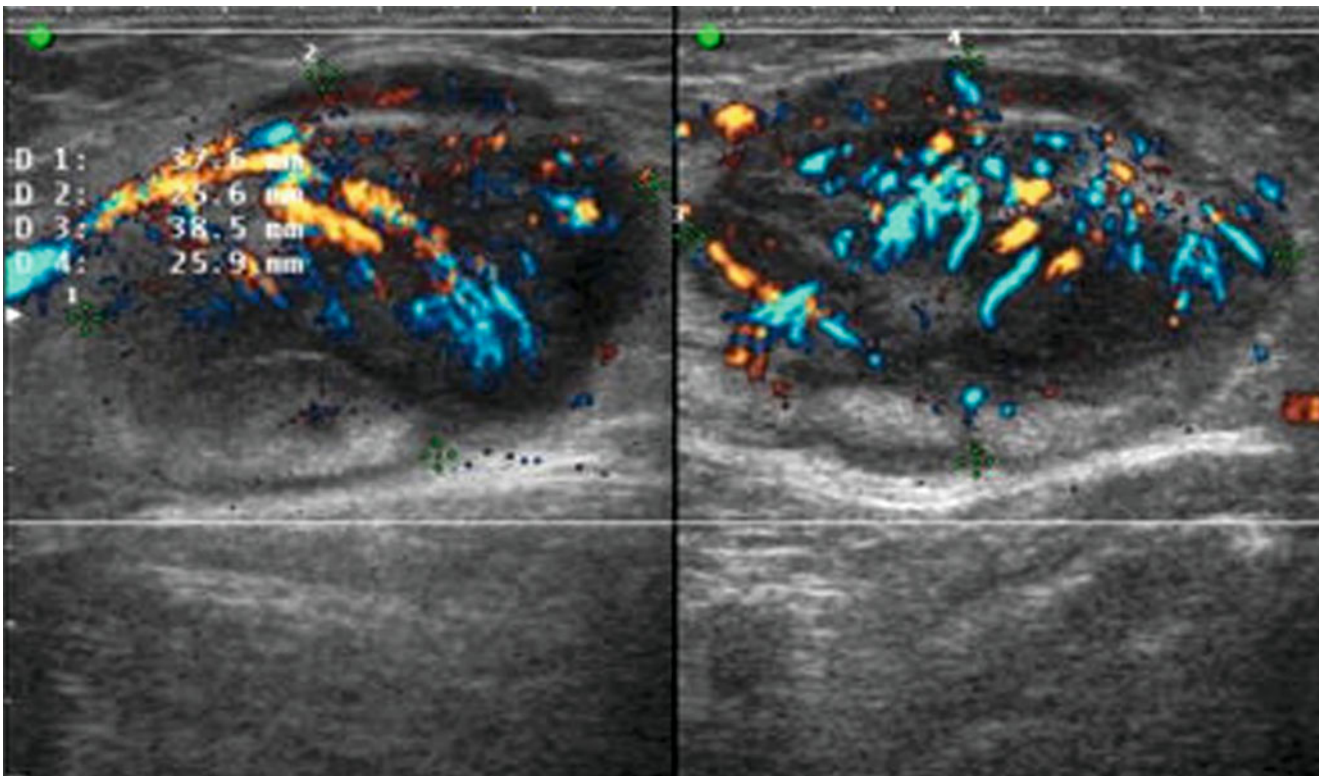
Benign lymphadenopathy. Directional power Doppler image. Granulomatous lymphadenopathy, proved using fine-needle aspiration cytology, and the typical appearance of a large lymph node with intensified vascularization
